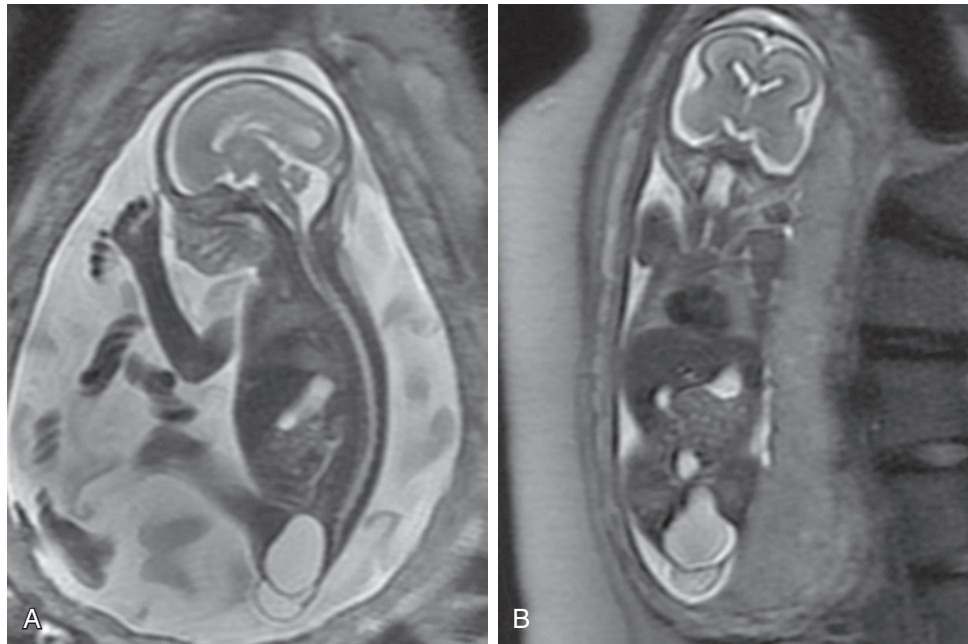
Sacrococcygeal teratoma. Fetal magnetic resonance imaging (T2 weighted) in the sagittal (A) and coronal (B) planes showing sacrococcygeal teratoma in a 24-week fetus.
